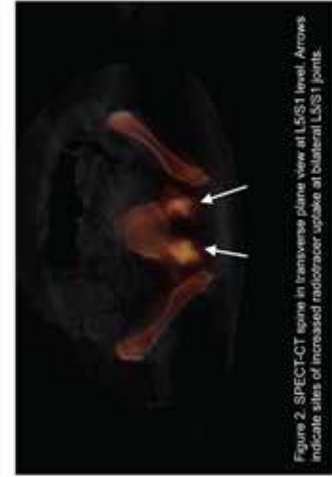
SPECT-CT spine in transverse plane view at L5/S1 level. Arrows indicate sites of increased radiotracer uptake at bilateral L5/S1 joints.
